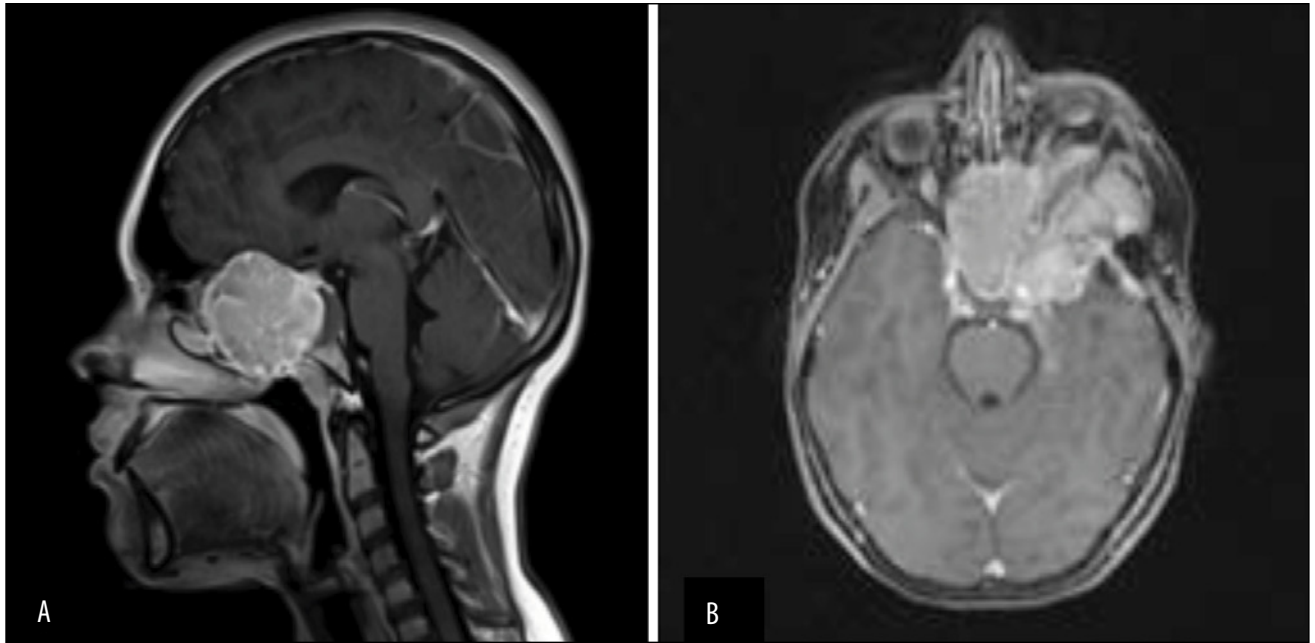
Craniocerebral MRI scan, sagittal (A) and axial (B) slices - expansive process involving the left sphenoidal wing, with ethmoidal and orbital, infratemporal and pterygomaxillary fossae invasion and intracerebral extranevaxial expansion into the antero-internal left temporal pole
